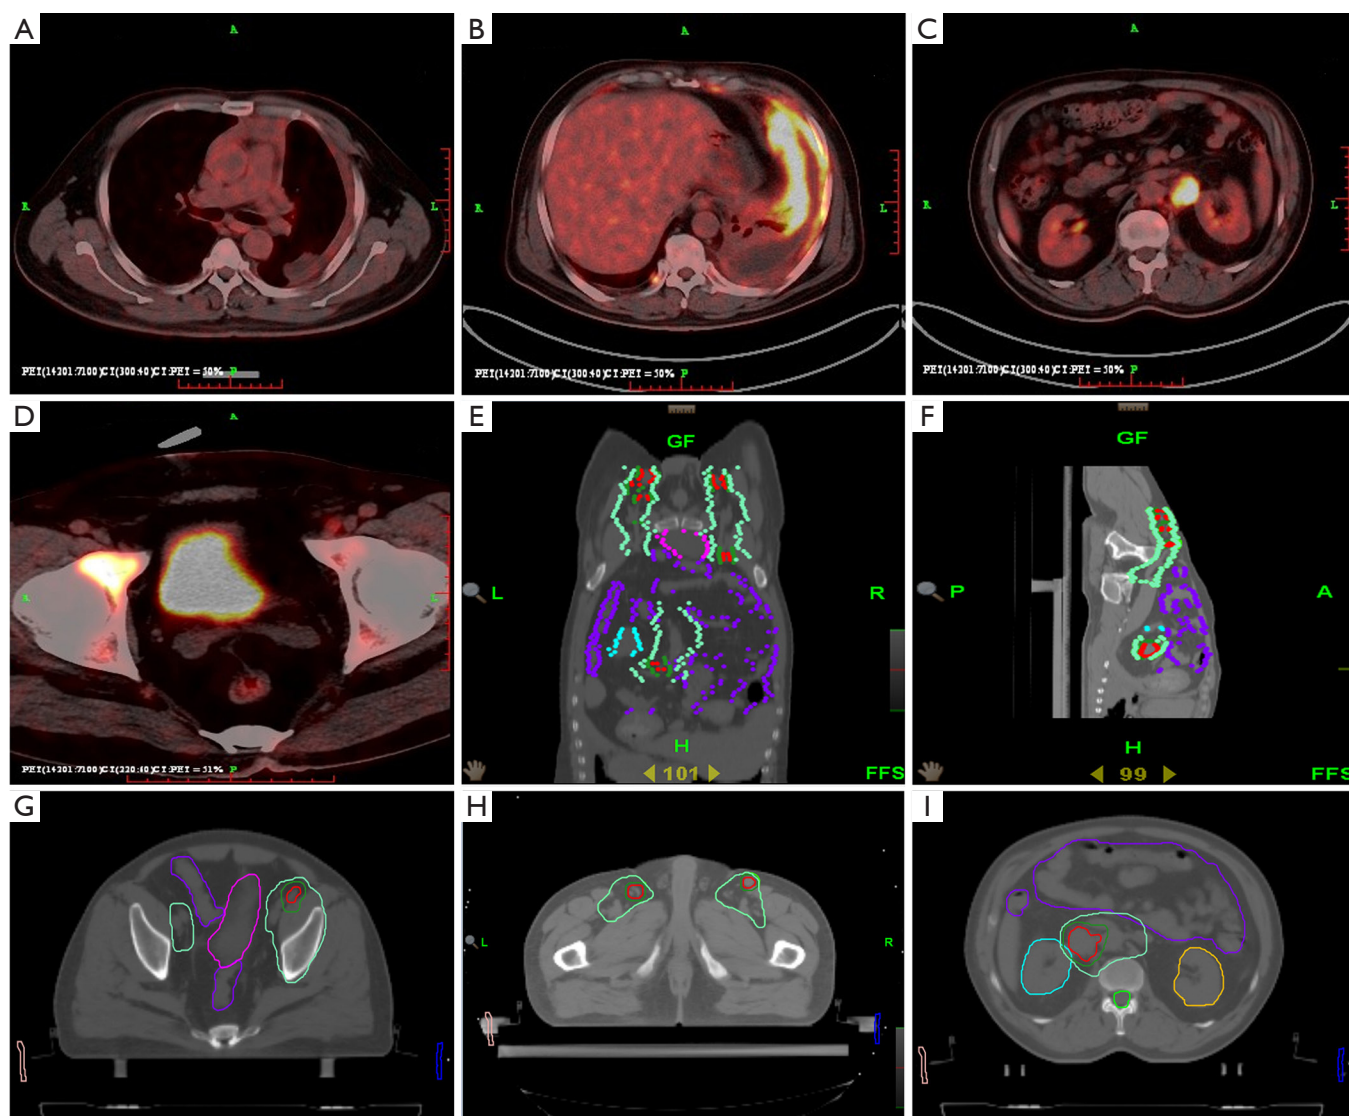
PET-CT reexamination images after the first radiotherapy and before TOMO therapy. (A) This mainly shows anterior mediastinal occupation and no significant increase in FDG metabolism, suggesting that after radiotherapy on the primary thymus lesion, the tumor was inactive. The shrunken mass also indicates the effectiveness of local radiotherapy. (B) Left pleura thickening, (C) retroperitoneal multiple lymphadenectasis, and (D) the right acetabulum showed an abnormal increase in FDG metabolism; metastasis was considered. TOMO schedule chart. (E) and (F) are systemic figures of the TOMO schedule, showing the whole radiotherapy target volume which included the (G) acetabulum, (H) inguinal lymph nodes, and (I) abdominal lymph nodes. TOMO, tomotherapy.
